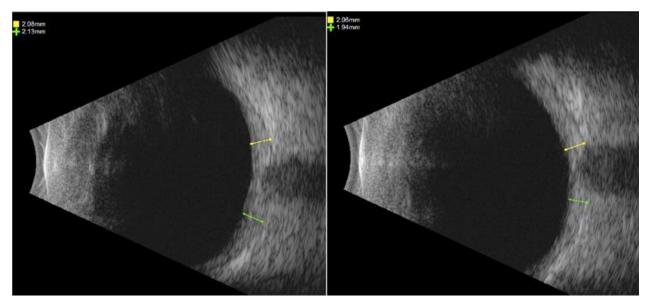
B-scan ultrasonography revealed an evident increase in the thickness of the sclero- choroidal complex at the posterior pole. In the right eye, the measurements ranged from 2.08 to 2.13 mm, while in the left eye, they ranged from 1.94 to 2.06 mm.
